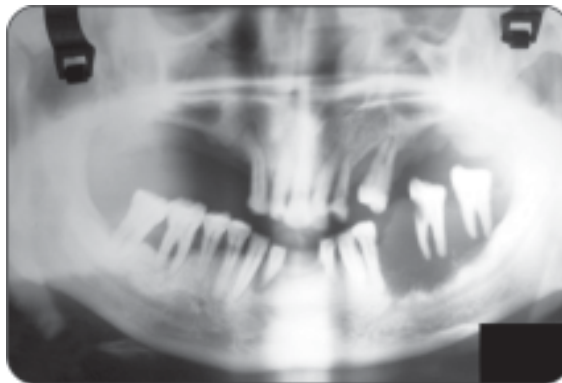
Radiograph of ameloblastic carcinoma
